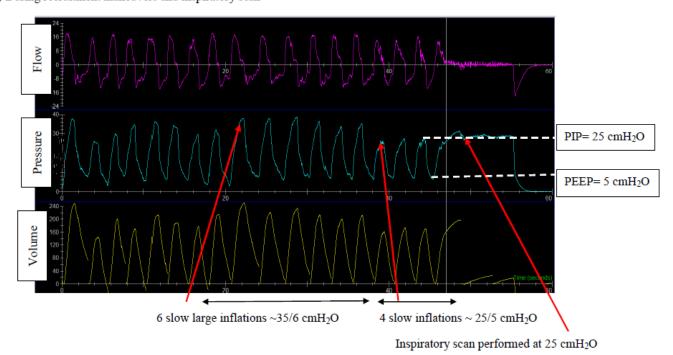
Screenshot of NICO₂® measurements during GA for chest CT scan
